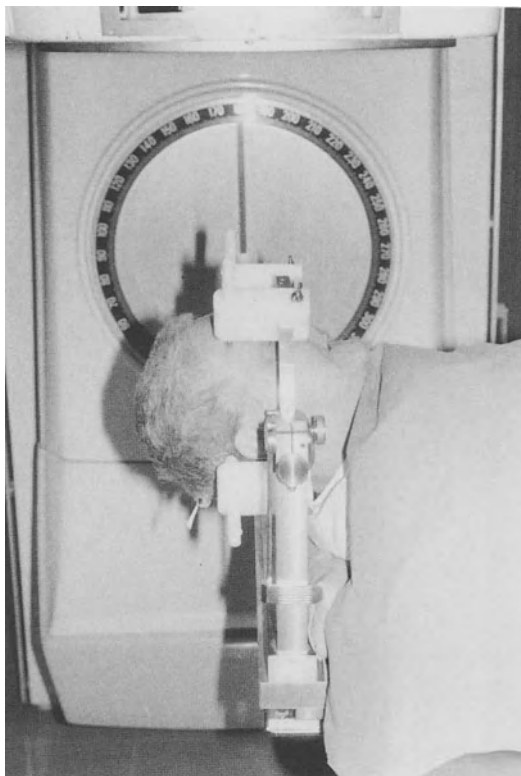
CT localization procedure
